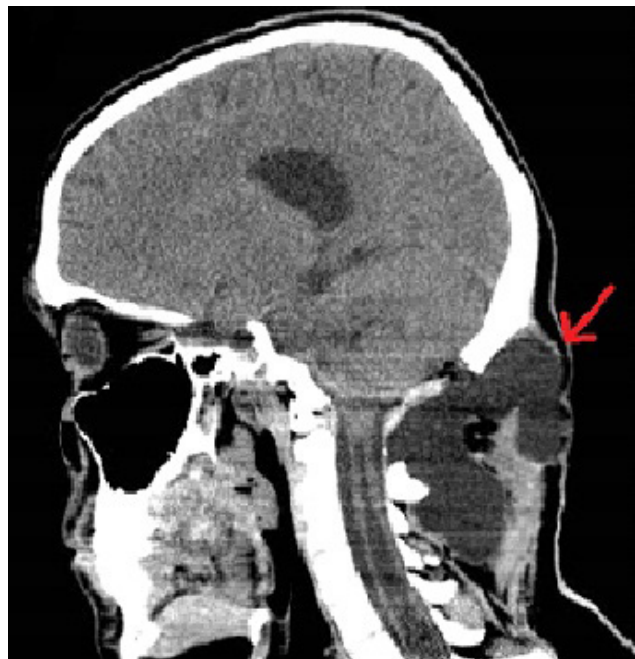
A sagittal CT scan. Pseudomeningocele (marked by arrow) — one of the post-op complications from Chiari malformation surgery
